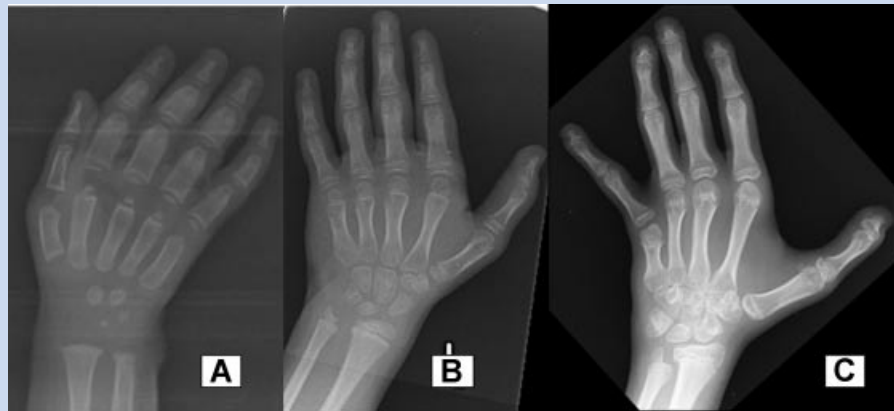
X-rays of hands at: (A) newborn (Patient 4); (B) 5 years (Patient 8); (C) 12 years (Patient 14).
